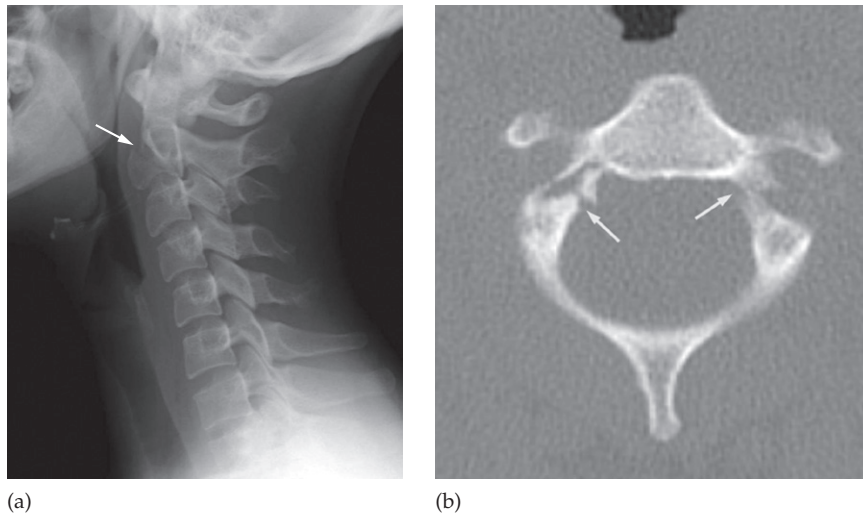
Hyperextension injuries. (a) Radiograph showing an extension teardrop fracture of C2 (arrow) with minimal associated prevertebral swelling (haematoma). (b) 'Hangman's fracture': axial CT showing the bilateral pars interarticularis fractures (arrows).
